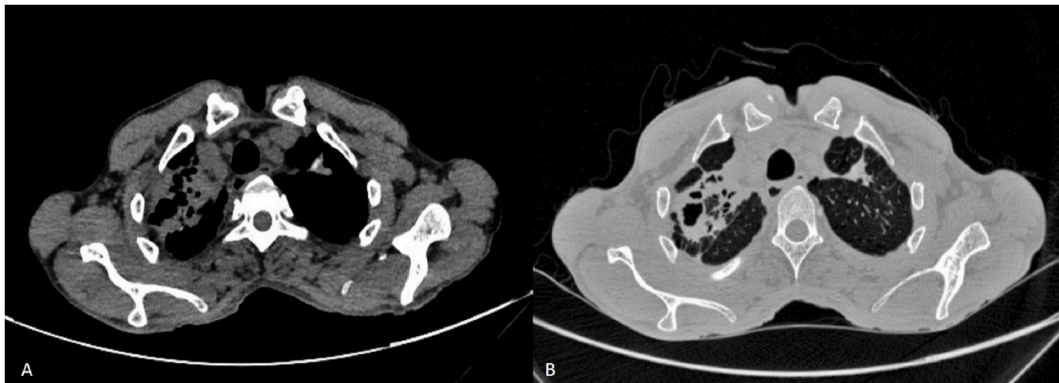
Case 1: CT showing cavitory lung lesion with surrounding fibrotic and bronchiectatic changes in right upper lobe (A) soft tissue window (B) lung window.
